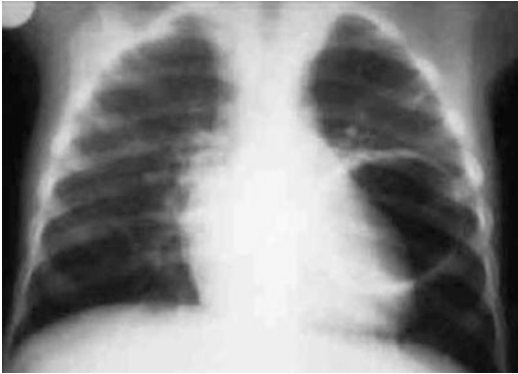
Pneumatocele. Chest X-ray in 10-month-old infant shows left upper lobe pneumatocele
